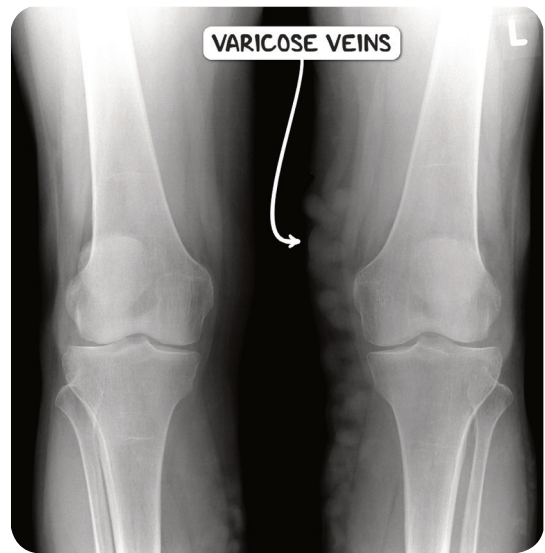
An X-ray image demonstrating varicose veins of the left leg.
